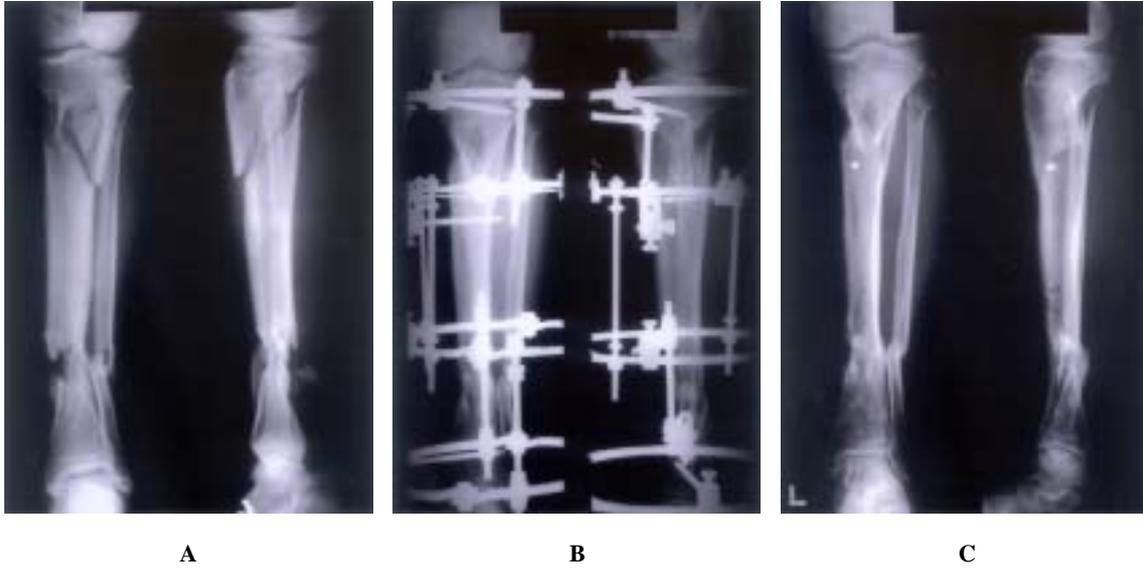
Preoperative anterior and lateral roentgenogram shows Meilis type III segmental tibial fracture of the left tibia.
